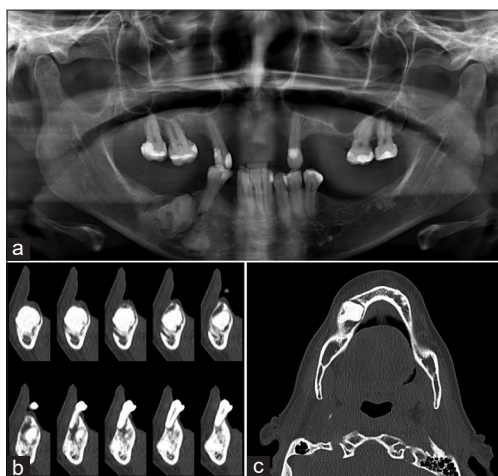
Preoperative panoramic radiograph and computerized tomography images. (a) Panoramic radiograph. (b) Coronal plane. (c) Axial plane
